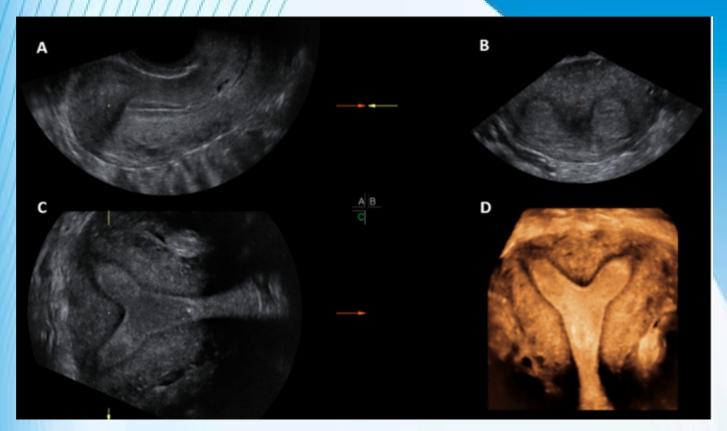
3D ultrasound scan of a subseptate uterus showing simultaneous display of longitudinal plane (A), transverse plane showing two endometrial echoes (B), coronal plane (C), unique for 3D ultrasound and Rendered view of coronal plane demonstrating subseptate uterus (D).
